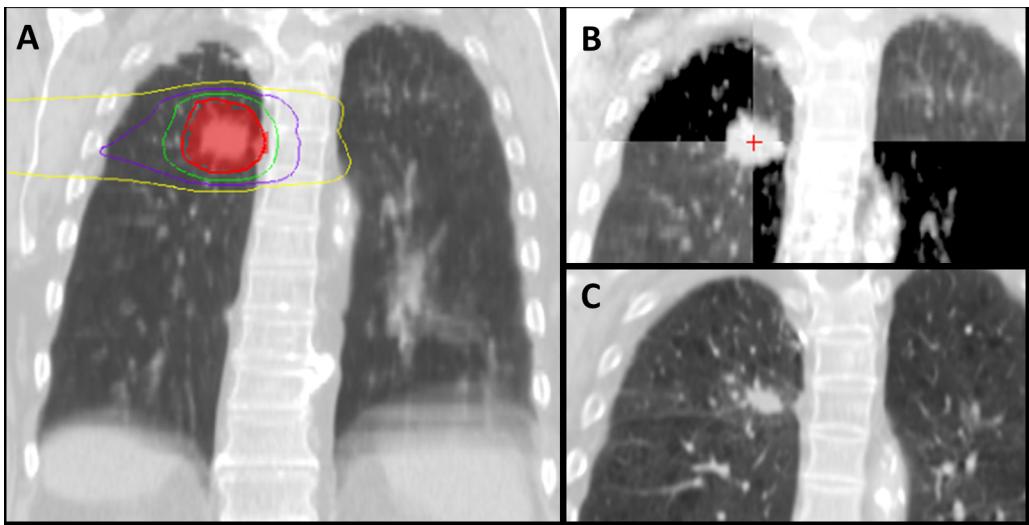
Stereotactic body radiotherapy (SBRT) for a T1N0 lung adenocarcinoma. (A) Four-dimensional CT average projection showing the SBRT plan. Red color wash represents the planning target volume (PTV), solid lines represent regions receiving doses of 60 Gy (red), 45 Gy (green), 30 Gy (purple) and 15 Gy (yellow), respectively. (B) Cone-beam CT done at time of treatment and aligned with planning CT scan to confirm setup accuracy. (C) Follow-up scan 2.5 years post-treatment, with stable area of fibrosis measuring 1.9 cm.
